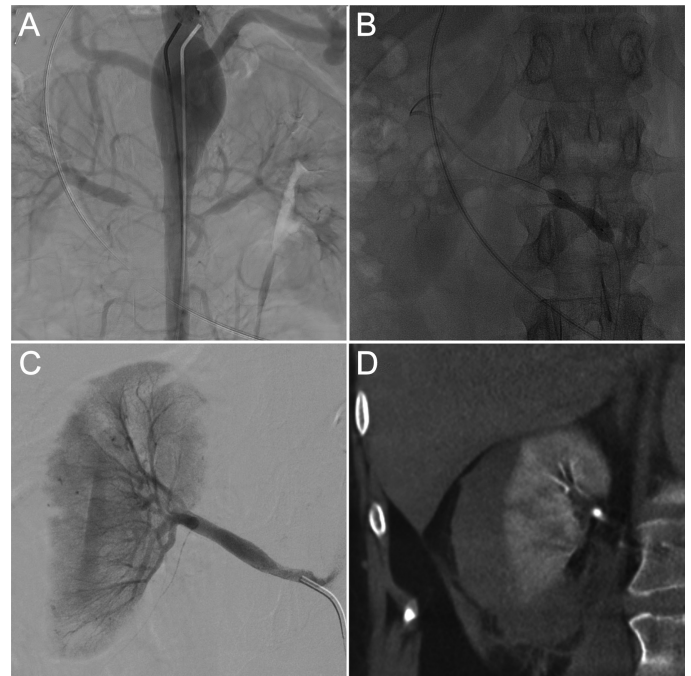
(A) Digital subtraction angiographic image of the aorta and bilateral renal artery showed the presence of bilateral renal artery stenosis, aortic narrowing, and dilation. (B) Angiographic image of the right renal artery during the balloon angioplasty procedure. (C) Digital subtraction angiographic image of the right renal artery after transluminal balloon angioplasty revealed normal renal artery caliber. Multisite microextravasations were also noted. (D) A computed tomography image obtained after 1.5 hours after the procedure showed the presence of extensive right renal subcapsular hematoma, compressing and displacing the renal parenchyma.
